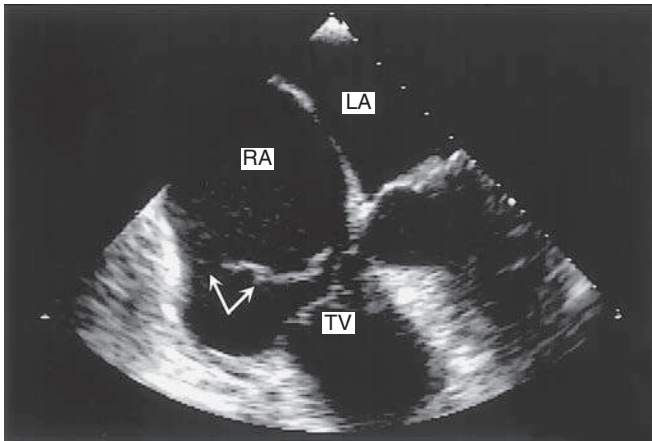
Echocardiogram (from the apical four-chamber view) of a 46-year-old man with cor triatriatum dexter. The perforate membrane (arrows) within the right atrium (RA) divides it into two chambers, with the distal chamber including the tricuspid valve (TV). LA, Left atrium.
